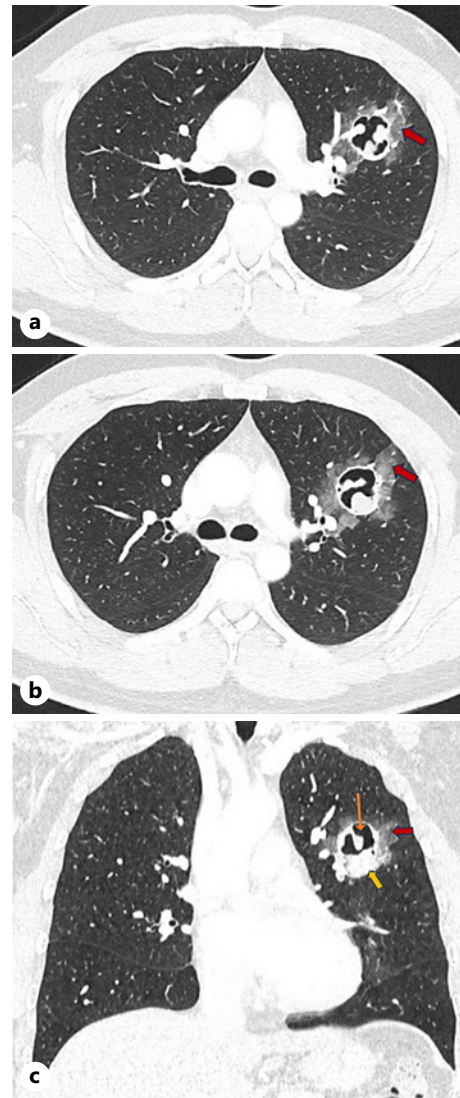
a, b First CT scan of the chest (Transverse Section): A cavitary lesion in the left upper lobe with an intracavitary multi-lobular opacity. Ground-glass changes also observed surrounding the cavity (arrow). c First CT scan of the chest (Coronal Section): A cavitary lesion in the left upper lobe with an intracavitary lobular opacity. Ground-glass changes were observed surrounding the cavity (red arrow). In the coronal plane of the CT scan, a wide variation in the thickness of the cavity wall was also noted, with the thickest margin noted on the inferior aspect (yellow arrow). A rim of air was also noted surrounding the intracavitary mass lesion (orange arrow).
